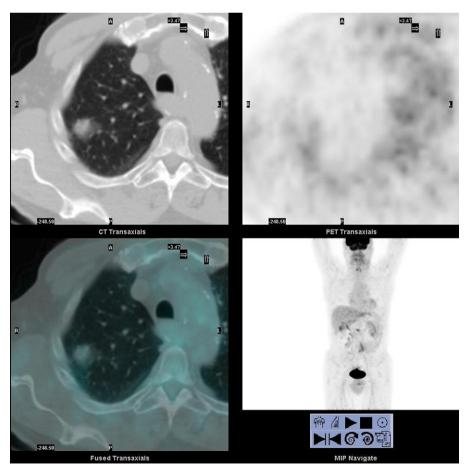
18F-FDG PET/CT images of a patient with a right BAC well showed at CT (upper right image) while FDG PET revealed faint uptake only (upper left PET and down right PET/CT fused images). MIP (multiple intense projection) on the down left position of the figure.
